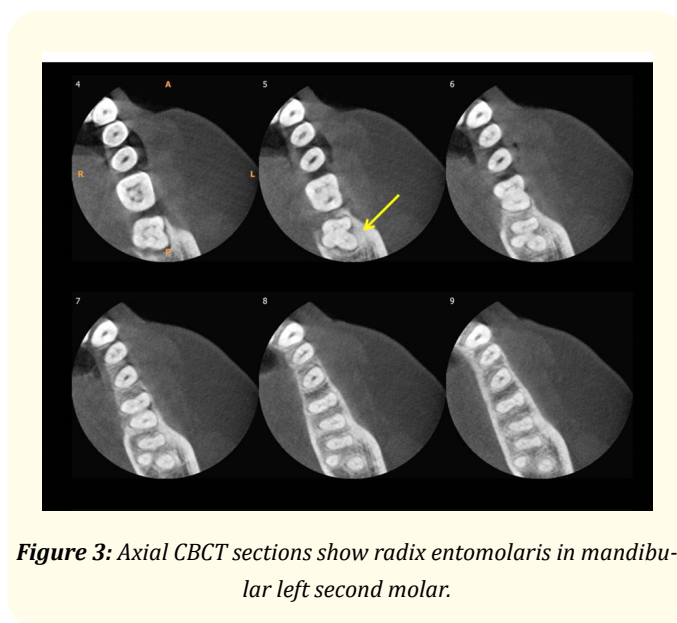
Axial CBCT sections show radix entomolaris in mandibular left second molar.
